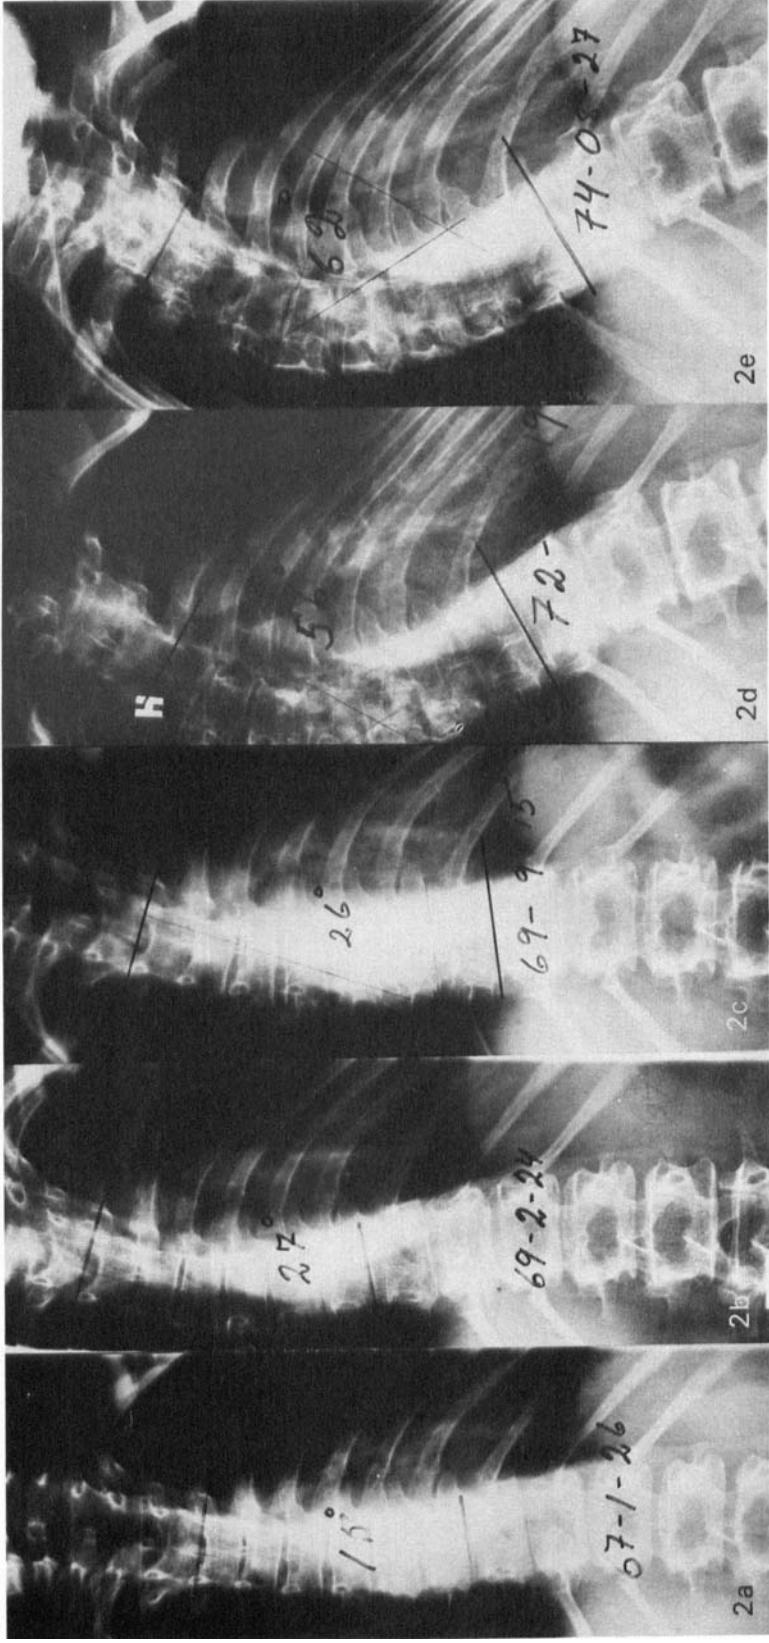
Progression of scoliosis determined on roentgenograms according to Cobb (1948).
